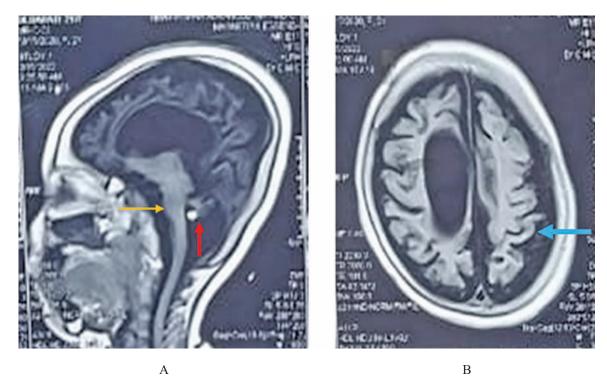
A) MRI of the brain sagittal section showed severe cerebellar atrophy (red arrow) and mild atrophy of pons (orange arrow). B) MRI of the brain axial section showed cerebral cortical atrophy (blue arrow).*
